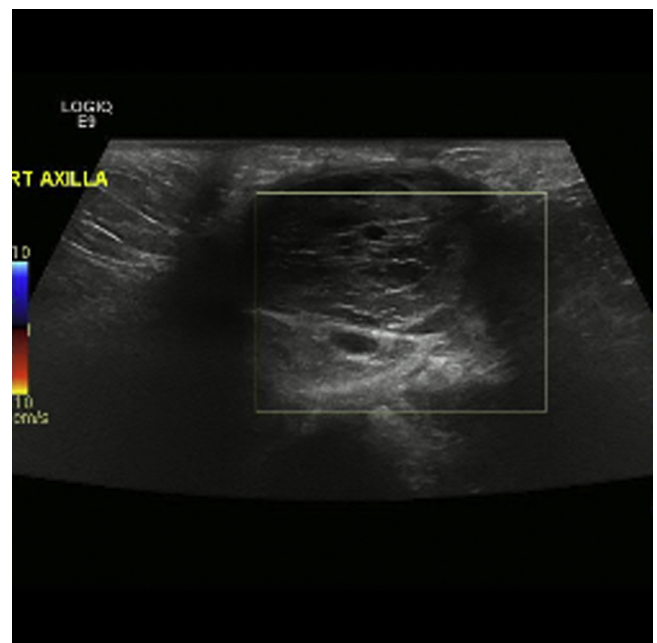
Intraoperative ultrasound of the axilla indicating dense, woody tissue with diffuse scarring from radiation therapy.
